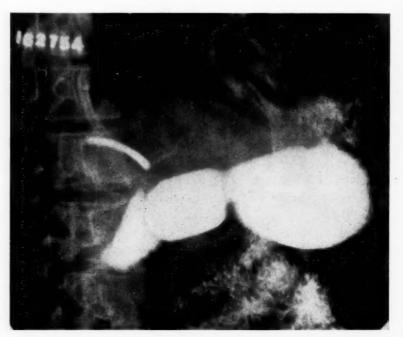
X-ray Film of Abdomen Following Ingestion of Barium The long metallic foreign body is present in the right upper quadrant.
